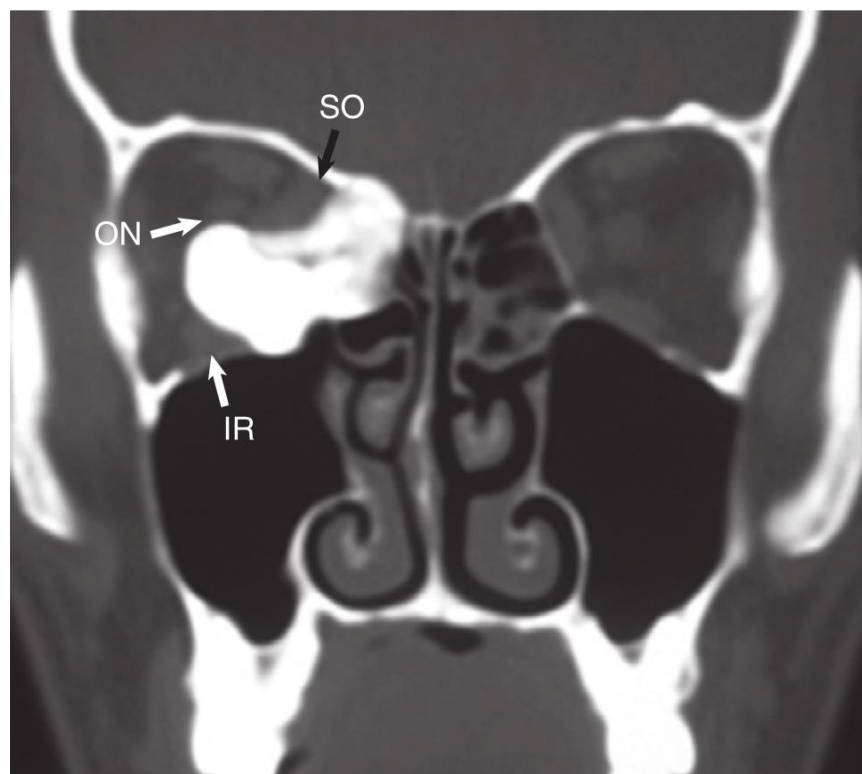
On a coronal computed tomography scan, a large ethmoid osteoma can be seen invading the orbit and displacing the optic nerve (ON), the superior oblique muscle (SO), and the inferior rectus muscle (IR). The high and quite homogeneous density is characteristic of the ivory variant. The lesion was resected via an endoscopic approach.
